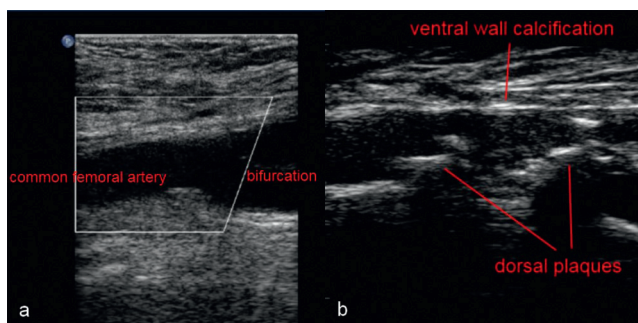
Ultrasound images. (a) Common femoral artery with almost no calcification in a 84 years old patient with suitable diameter for transfemoral approach (later successfully treated with a 26 mm Edwards SAPIEN valve) (b) Heavily calcified common femoral artery of a 74 years old patient with typical dorsal plaques reducing arterial lumen and ventral wall calcification (later on successfully treated with 26 mm Edwards SAPIEN valve via transapical approach).
